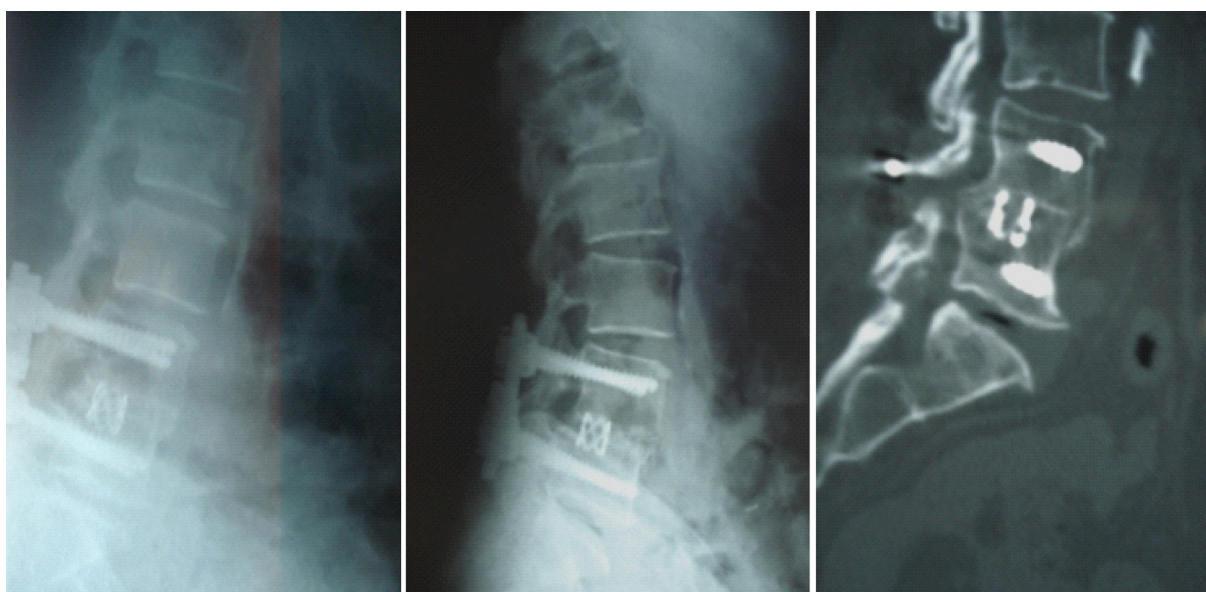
Postoperative flexion and extension lateral xrays and CT.
